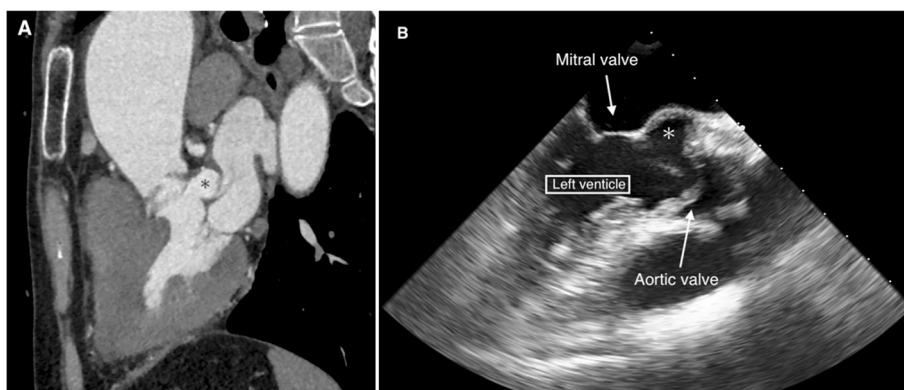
Preoperative computed tomography and echocardiography. Preoperative computed tomography (A) showing the cavity (asterisk) at the left ventricle outflow tract between the noncoronary cusp of the aortic valve and anterior leaflet of the mitral valve. Preoperative echocardiography (B) also showing the cavity (asterisk) at the same position. This was a pseudoaneurysm of the mitral-aortic intervalvular fibrosa
